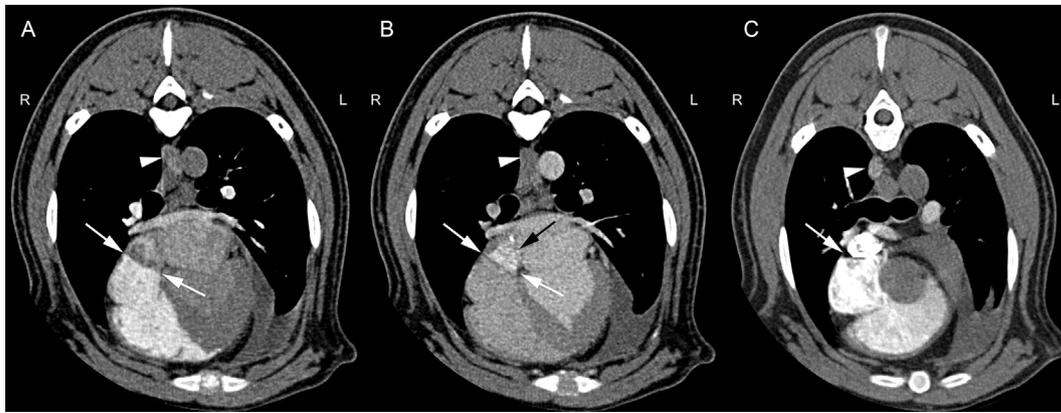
A to C: Transverse slices of angiographic computed tomography studies of the heart in diastole after A: cephalic injection in a caudal location, B: saphenous injection at the same level as A, C: cephalic injection in a further cranial location. A: The right atrial membrane (white arrows) oriented in a dorsal-oblique plane separated the systemic venous sinus from the right atrial body identified by the auricle. The dilated azygos vein (white arrow head) and the left atrium enhanced faintly. B: Saphenous injection resulted in enhancement of the other side of the membrane (white arrows). The contrast medium escaped through the patent foramen ovale (black arrow) into the left atrium and simultaneously contributed to the enhancement of the main compartment of the right atrium. The azygos vein (white arrow head) did not enhance. C: The well-defined membrane (white arrow) allowed the contrast medium to reach the main right atrial compartment through a small opening at this cranial level. The dilated azygos vein (white arrow head) contained a small amount of contrast medium.
